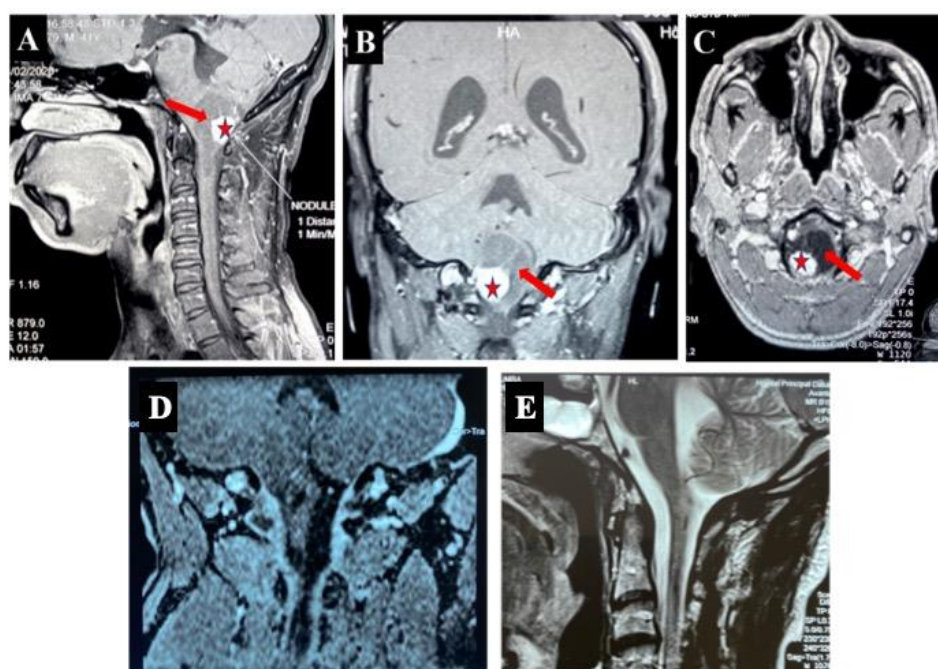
MRI of patient 4 showing a mixed intrabulbar cystic tumor (red arrows A, B, and C) with fleshy mural nodule (red star A, B, and C) and total excision leaving a residual cavity (D and E).
